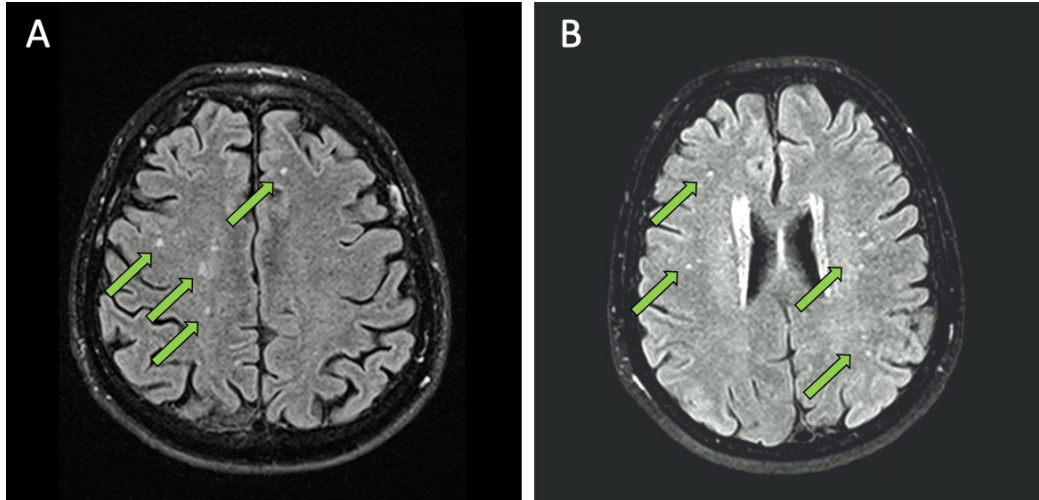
MRI-detected (FLAIR sequence) disseminated hyperintense cerebral lesions localized in frontal and parietal lobe white matter in two ablation-naïve patients with non-valvular atrial fibrillation (A and B)
